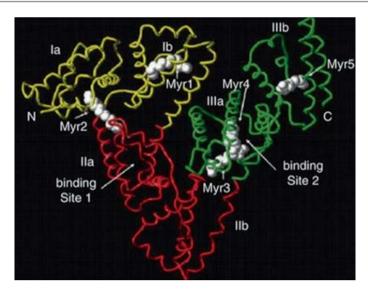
X-ray structure of human serum albumin (Reprinted with permission from Kratz [5]. Proceedings of the Tenth European Symposium on Controlled Drug Delivery)
